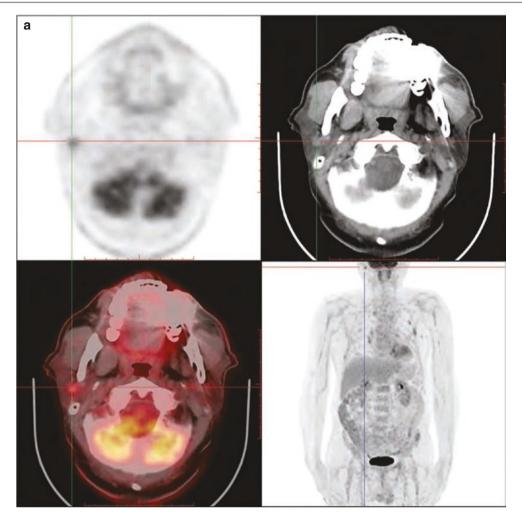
¹⁸F-FDG PET/CT images of pleomorphic adenoma of the right parotid gland. (a) PET/CT image of hypermetabolic nodules of the right parotid gland; (b) PET/CT image of hypermetabolic nodules of the right parotid gland. PET/CT showed a round slightly high-density
